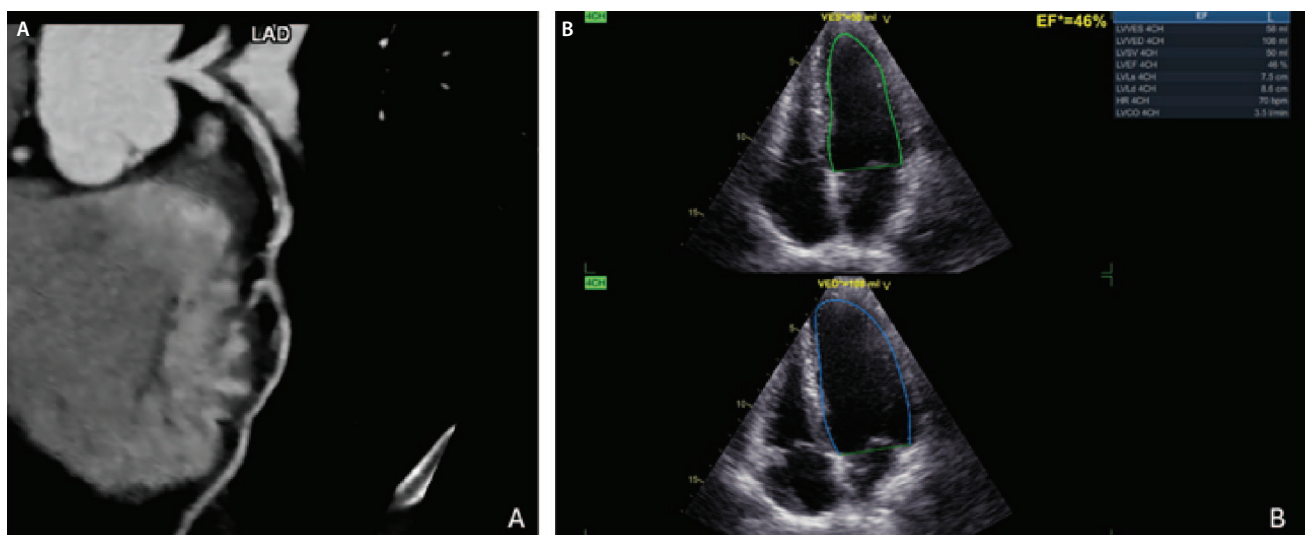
A) Multislice spiral computed tomography (MSCT) coronarography of the left anterior descending artery (LAD) showing sub-occlusive stenosis with soft plaque. B) Ejection fraction calculation after initiation of heart failure therapy and successful percutaneous coronary intervention in the LAD.
